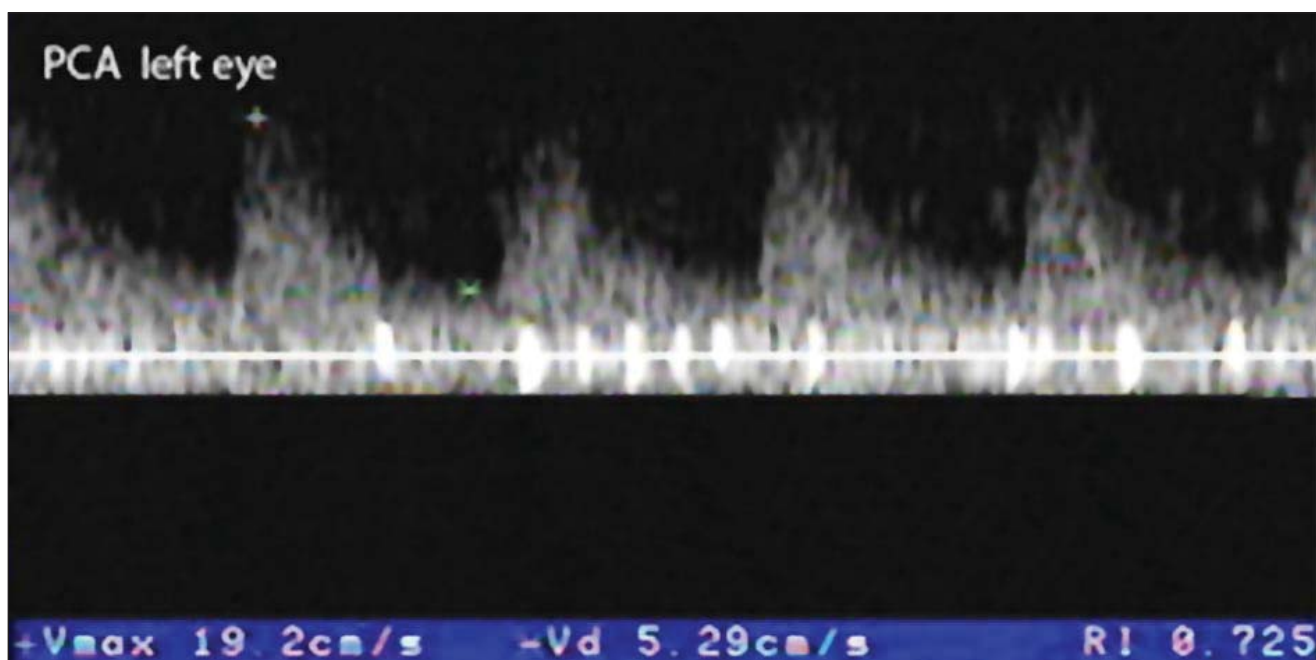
a, b. Patient TL-Spectral Doppler analysis of posterior ciliary arteries (PCA).
